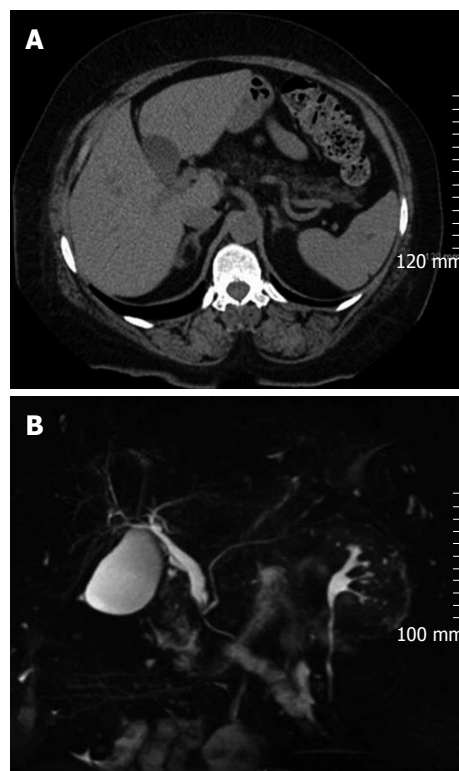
Radiological images of the abdomen. A: Computed tomography scan without contrast demonstrating the gallbladder to the left of the falciform ligament; B: Magnetic resonance cholangiopancreatography showing a dilated common bile duct on coronal view.
